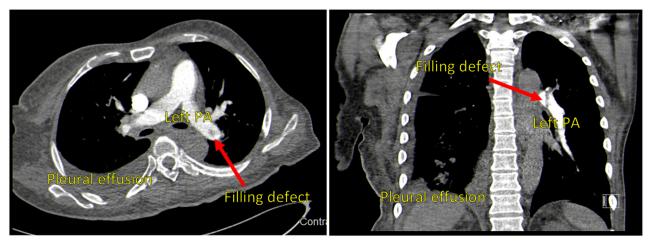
Chest contrast-enhanced CT in axial and coronal displays demonstrates a filling defect (*arrow*) in the distal left main pulmonary artery (PA).
